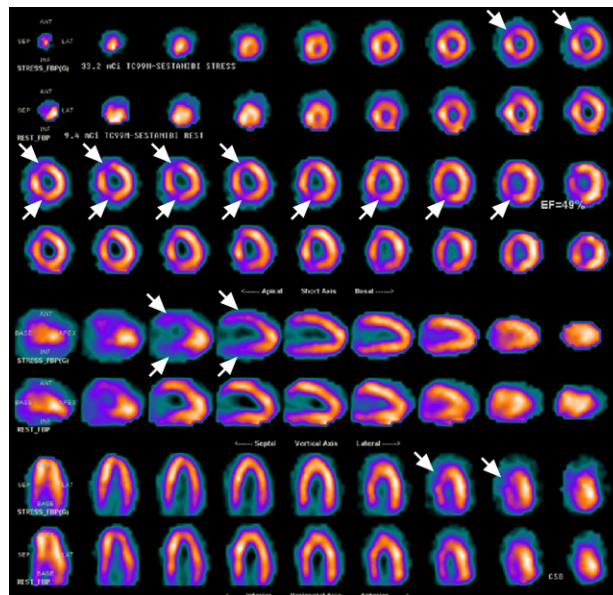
Single-photon emission computed tomographic scan shows ischemia (arrows) in the mid anteroseptum and inferior septum during stress.
